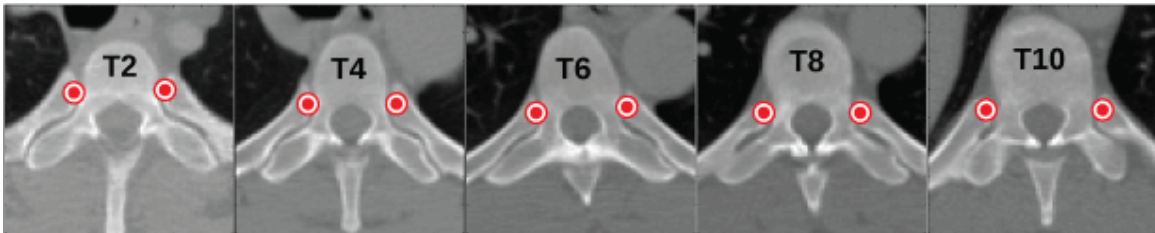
Rib end landmark placement at the proximal (to the spine) rib end for ribs 2, 4, 6, and 8. Each image shows a plane perpendicular to the spinal canal that is resampled from the original CT volume.
